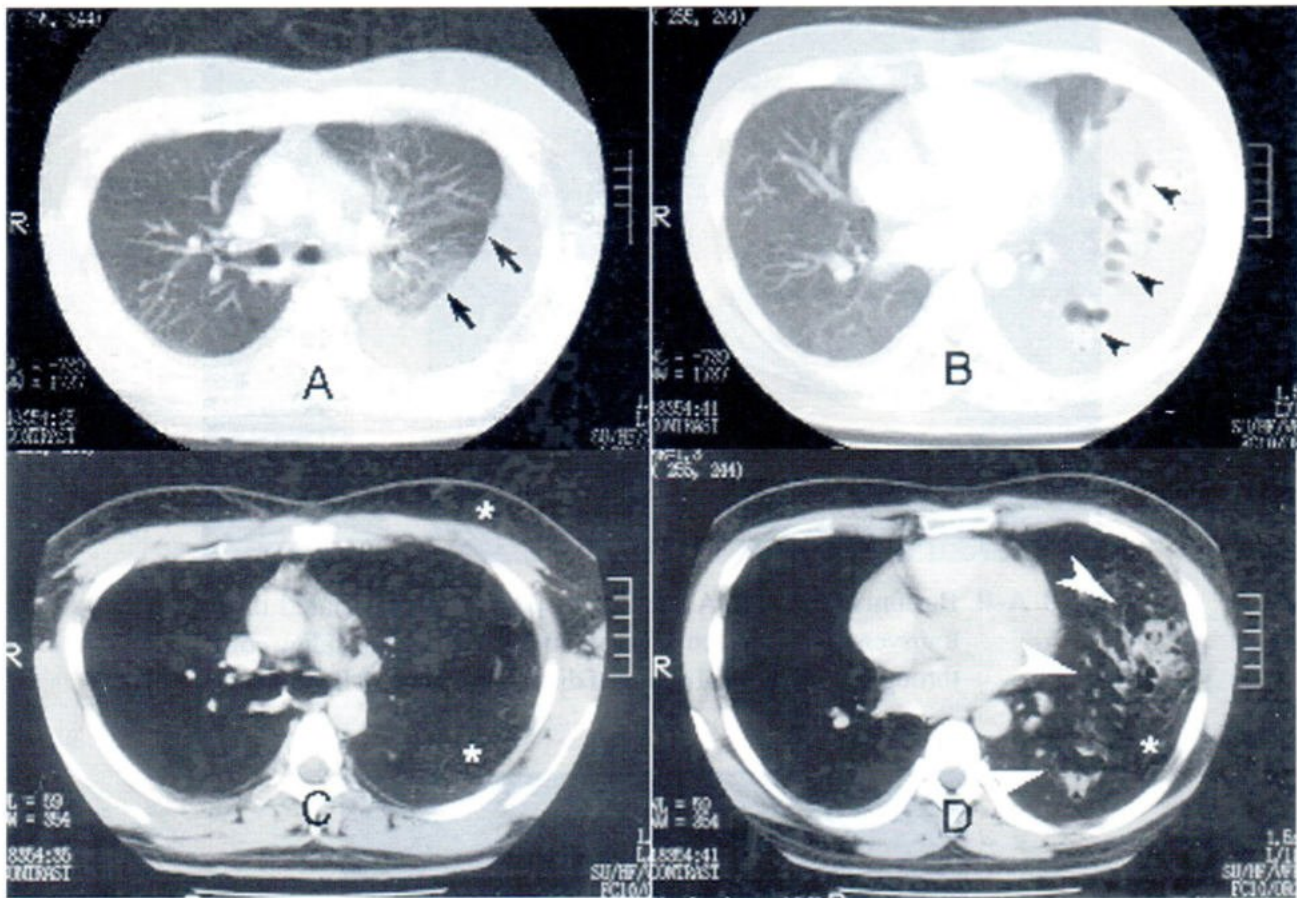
(A- D) Thoracic CT scans :
